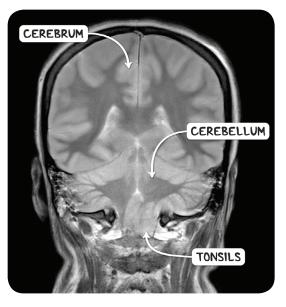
An MRI scan of the head in the coronal plane demonstrating herniation of the cerebellar tonsils secondary to hypoxic brain injury.
